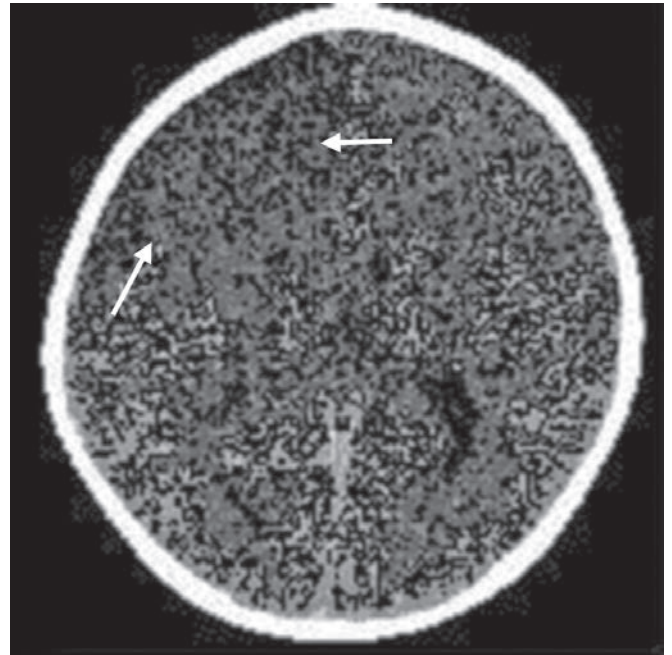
CT brain of a 12-year-old showing acute infarct involving the right internal carotid (IC) artery territory. Note the loss of grey white differentiation
